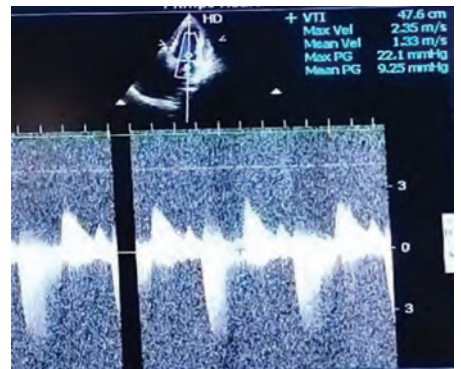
Postoperative echocardiography showing mitral valve (MV mean PG 9.2 mm Hg)
